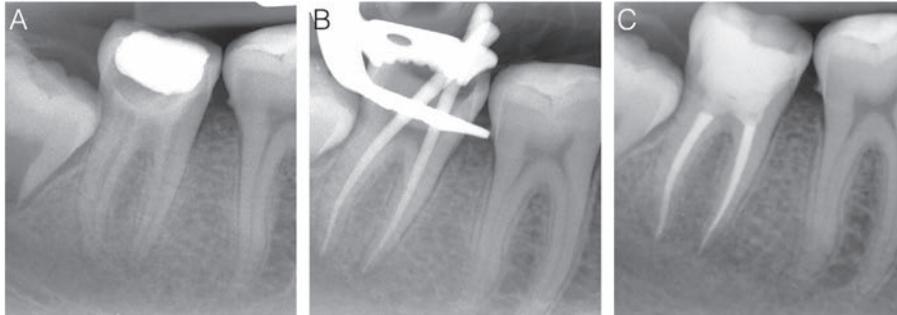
(A) Pre-operative periapical radiograph showing a good residual structure and small periapical lesions; (B) working length with gutta-percha points; (C) final periapical radiograph showing a good compaction of endodontic obturation.
